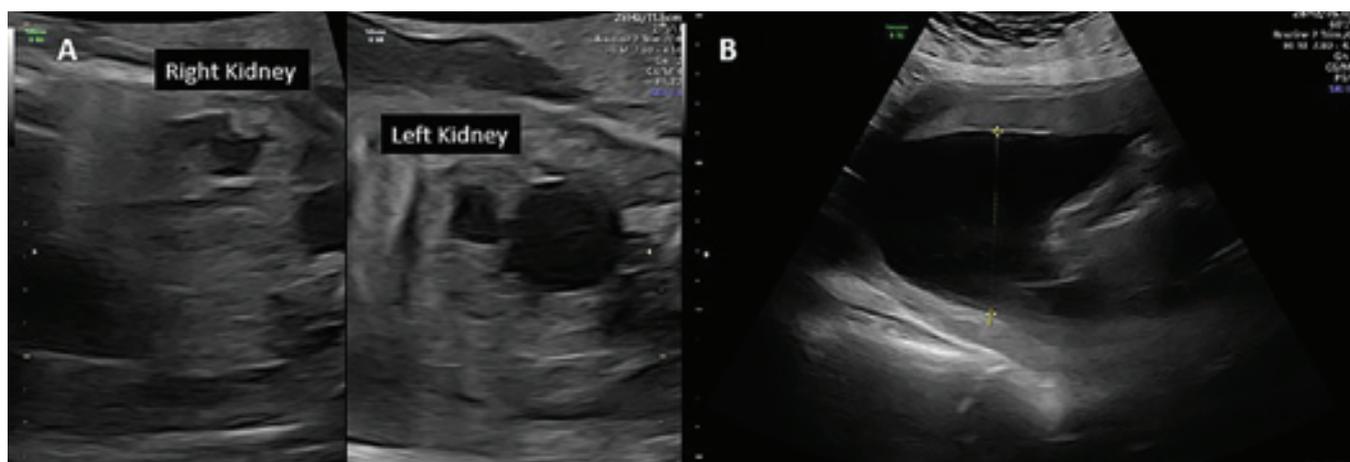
Ultrasound at 15 days after laser fulguration of the posterior urethral valves.
